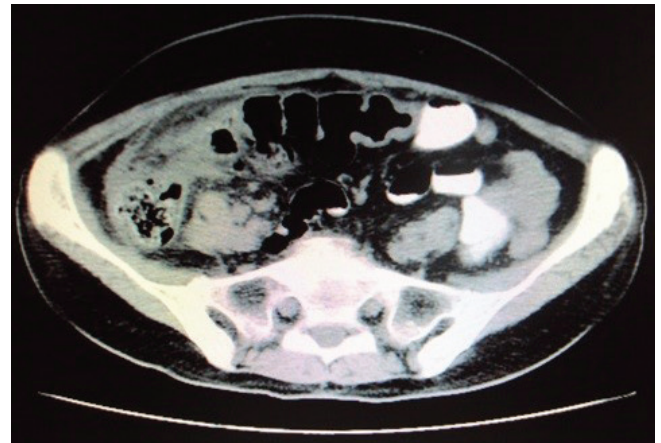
Contrast-enhanced computed tomography of the abdomen, showing segmental parietal wall thickening of the ascending and transverse colon
